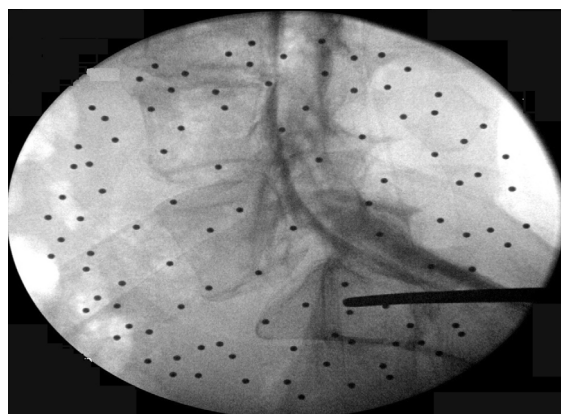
Fluoroscopy of lateral X-ray with addition of contrast to delineate nerve roots. Drill entry point posterior to iliac-cortical density shown.
